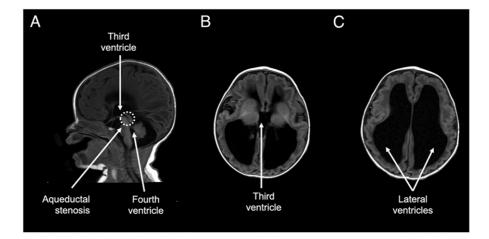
Aqueductal stenosis is a common cause of obstructive congenital hydrocephalus. T1-weighted fluid-attenuated inversion recovery magnetic resonance imaging of a 1-day-old infant. A. Sagittal view shows the stenosis of the central aqueduct (dotted circle) between the third and fourth ventricles. Axial views show increased ventricle size of the third ventricle (B) and lateral ventricles (C). This patient presented with signs of bulging fontanelles.
